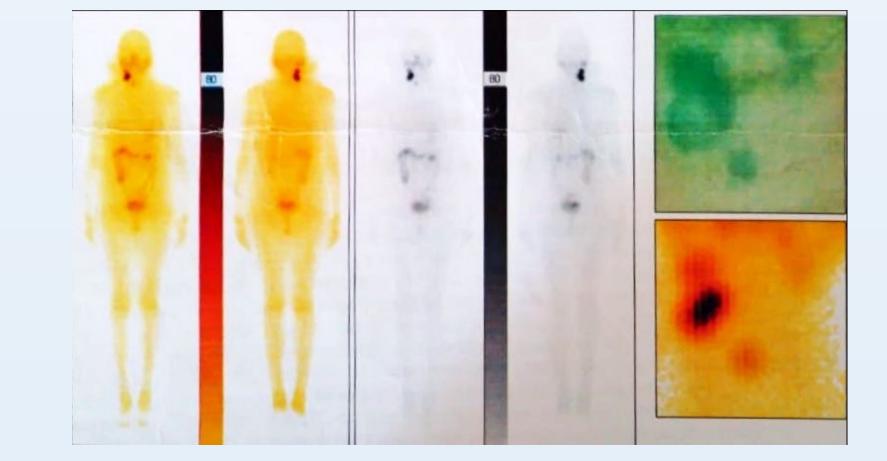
Whole body and specific scintigraphy after operation, The accumulation of radioiodine is visualized in three zones of the neck, most likely corresponding to the right lobe/isthmus rest.
